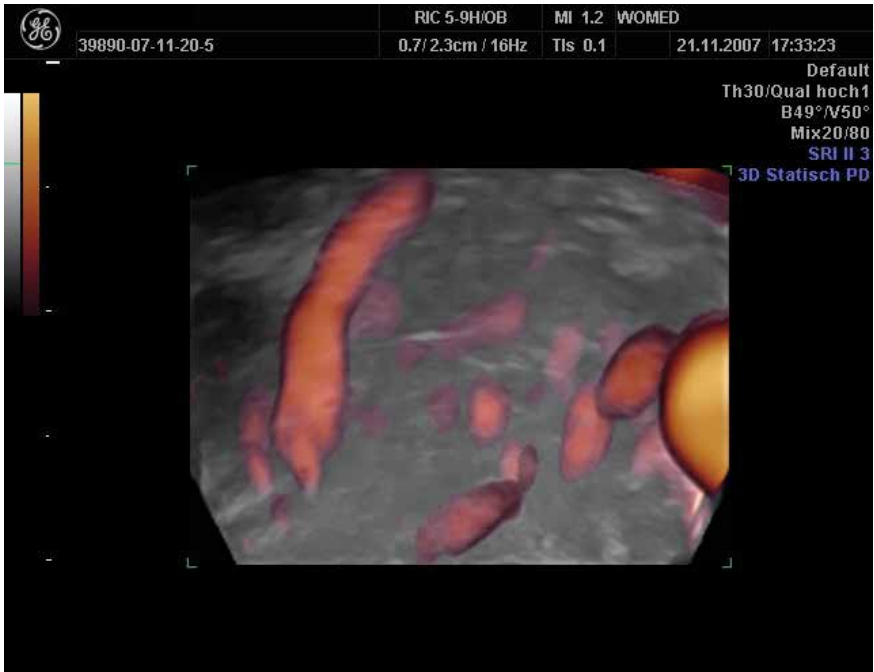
Case 1. Normal thyroid seen in 3-D power Doppler modulus using a vaginal transducer. The thick vessel corresponds to a laryngeal artery
